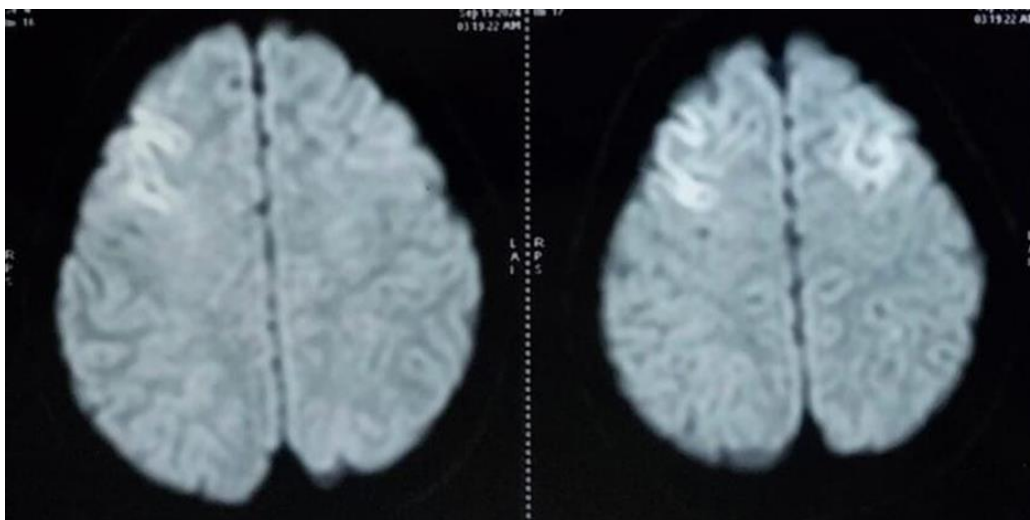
Diffusion weighted magnetic resonance image showing lesion in both frontal lobe (right > left)
